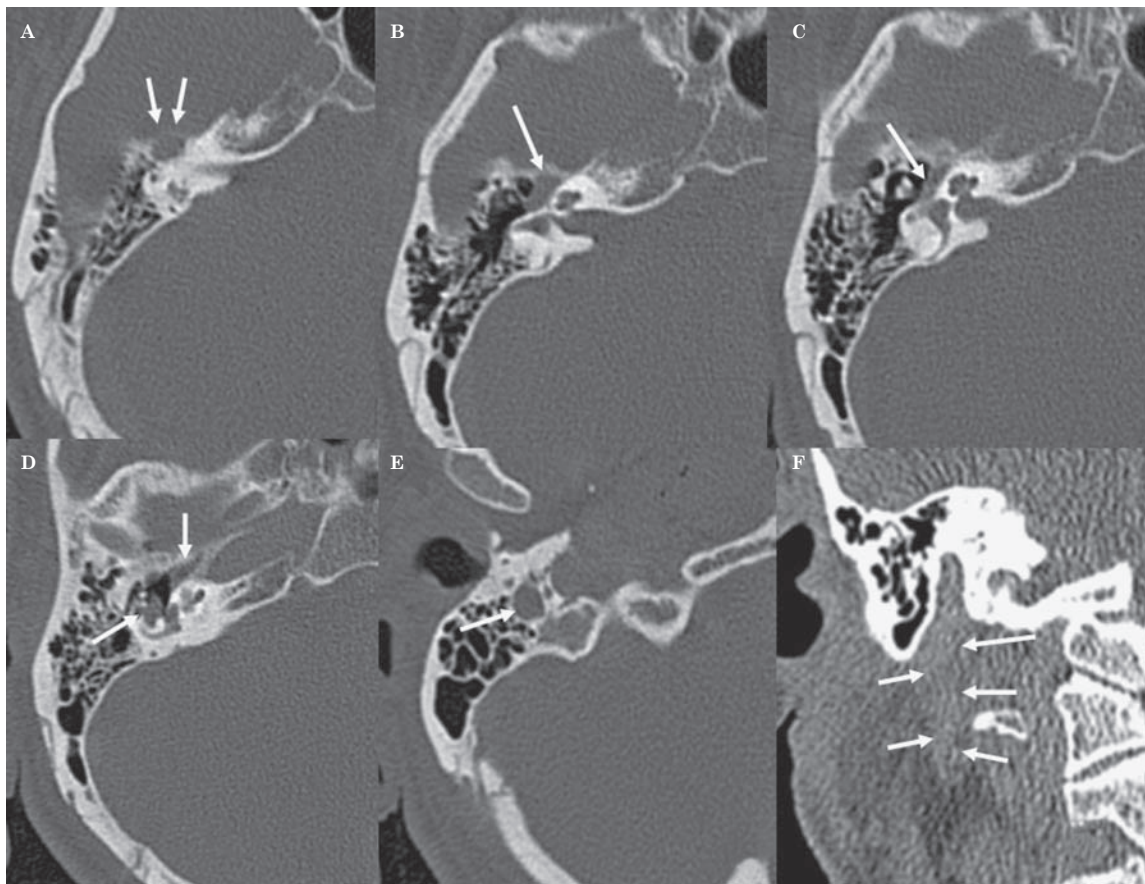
Axial HRCT image (A) shows an ill-defined curvilinear hyperdense band (arrow) indicating the impression of enlarged right geniculate ganglion on the bone. Thickened intratemporal horizontal and vertical segments of the facial nerve (arrows) (B-E) are demonstrated on sequentially. The coronal HRCT image (F) obtained at the level of stylomastoid foramina shows foraminal expansion and thickening of the nerve (arrows) along the extratemporal portion through the parotid gland.
